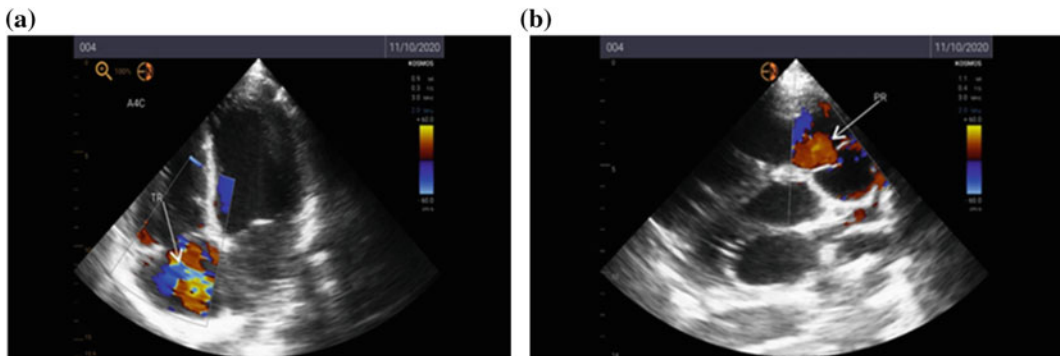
a A4C view with color Doppler showing severe tricuspid regurgitation in an SS sickle cell patient. b modified PSAX view aortic level with color Doppler
